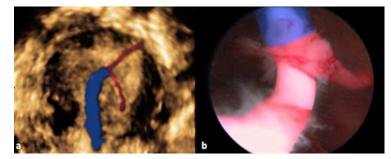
Comparison of 3D-Ultrasound (a) and (b) Hysteroscopic view of the malpositioned IUS. The IUS's arms are shown in red, and the stem is in blue color.
